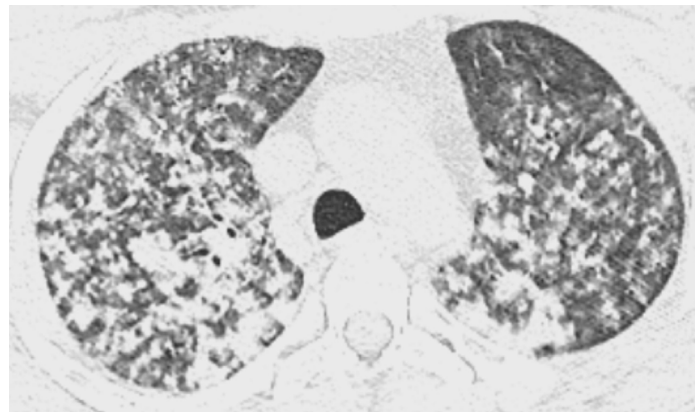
Representative image of chest (HRCT) showing extensive patchy alveolar consolidations with a peribronchovascular distribution, and areas of ground glass opacities (GGOs), in both lungs. The described lesions are mostly indicative of (DAH).
